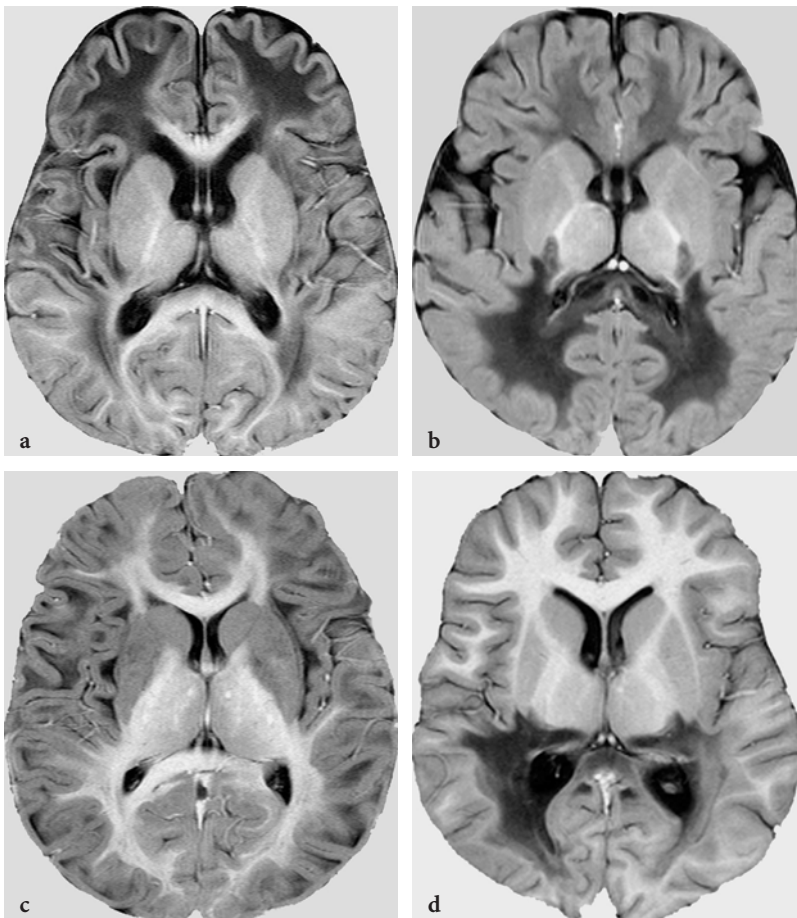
Various progression patterns in leukodystrophies on axial T1-weighted inversion recovery images. a Antero-posterior gradient of the white matter disease in van der Knaap disease. b Postero-anterior gradient of the white matter disease in Krabbe disease. c Centripetal progression pattern in L-2-hydroxyglutaric aciduria. The subcortical structures are completely demyelinated; the central white matter is preserved. d Centrifugal progression pattern in X-linked adrenoleukodystrophy. In this case, an additional postero-anterior gradient is also conspicuous
